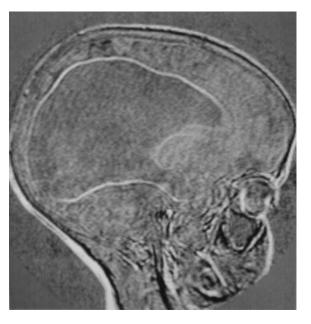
Subtraction image from two MRI examinations in a child with hydrocephalus. The white border around the ventricle indicates that the ventricle has shrunk between the examinations
